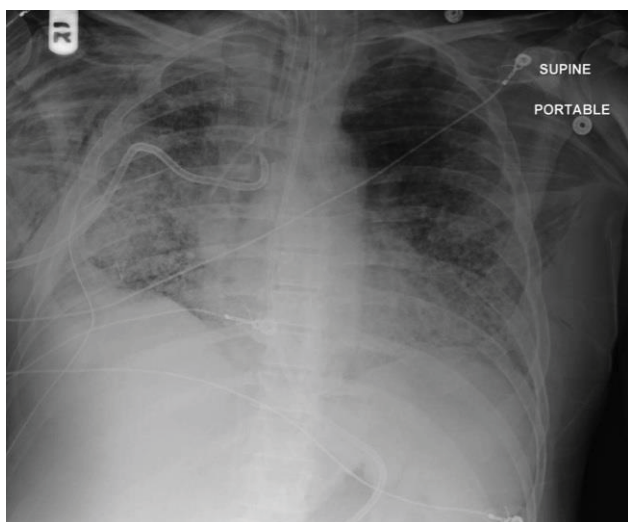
Chest X-ray showing pigtail in the right mainstem bronchus - without arrows.
